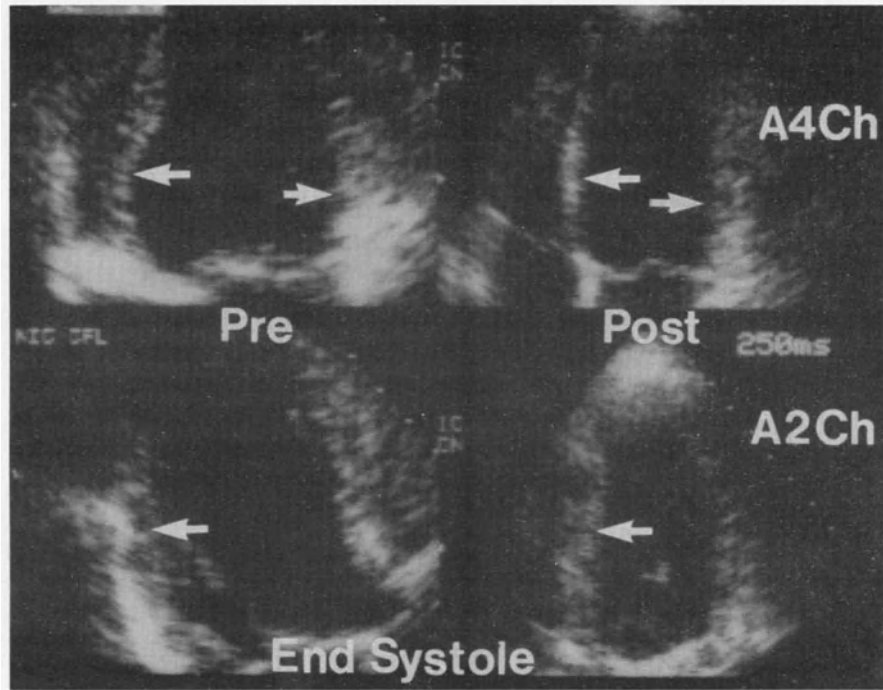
Side-by-side comparison of resting end-systolic apical 4-chamber (A4Ch) and apical 2-chamber (A2Ch) images before and after revascularization. The inferior, lateral and septal walls are seen to be akinetic initially, with improvement after revascularization (arrows). Reproduced with permission of the American Journal of Cardiology.
